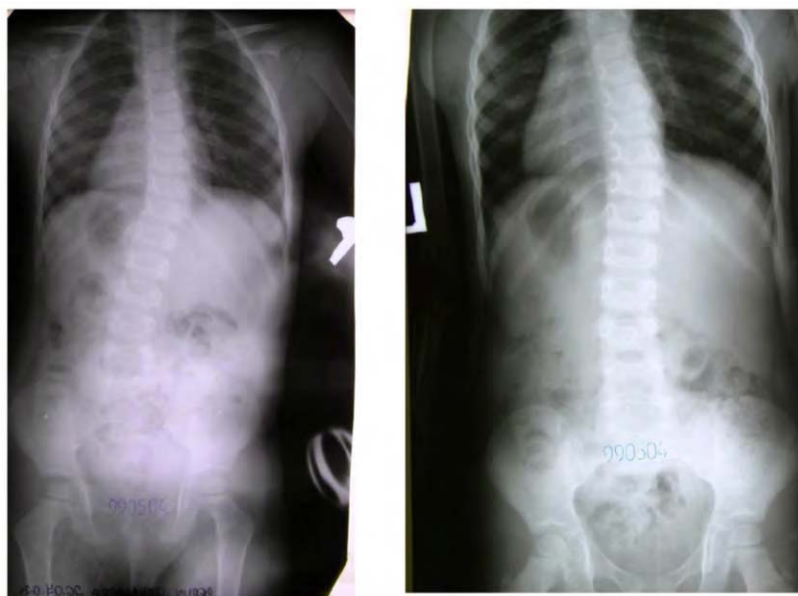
Girl, history number: 990504 (2a) X-ray examination at 3-yr old of life shows beginning of I-st epg of the so-called idiopathic scoliosis – “S” double scoliosis. (2b) Two years later - during new rehabilitation treatment.
